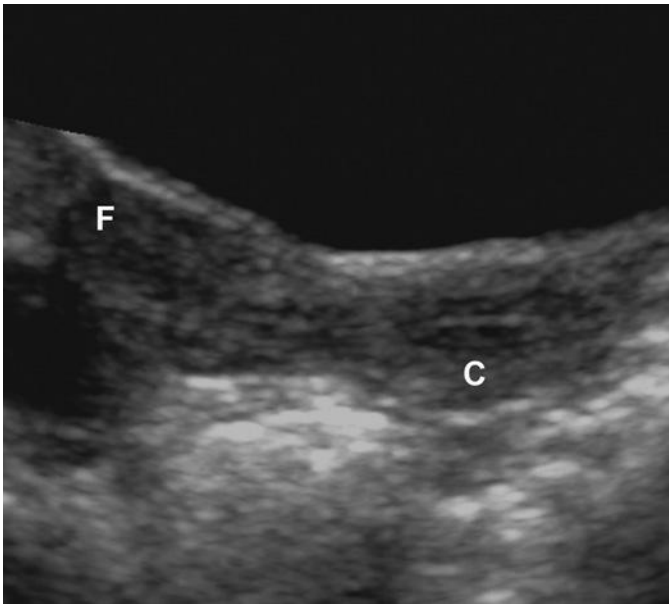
Normal uterus in a 19-month-old girl. Sagittal ultrasound image depicts a fundus (F) that is similar in thickness and length to the cervix (C).
